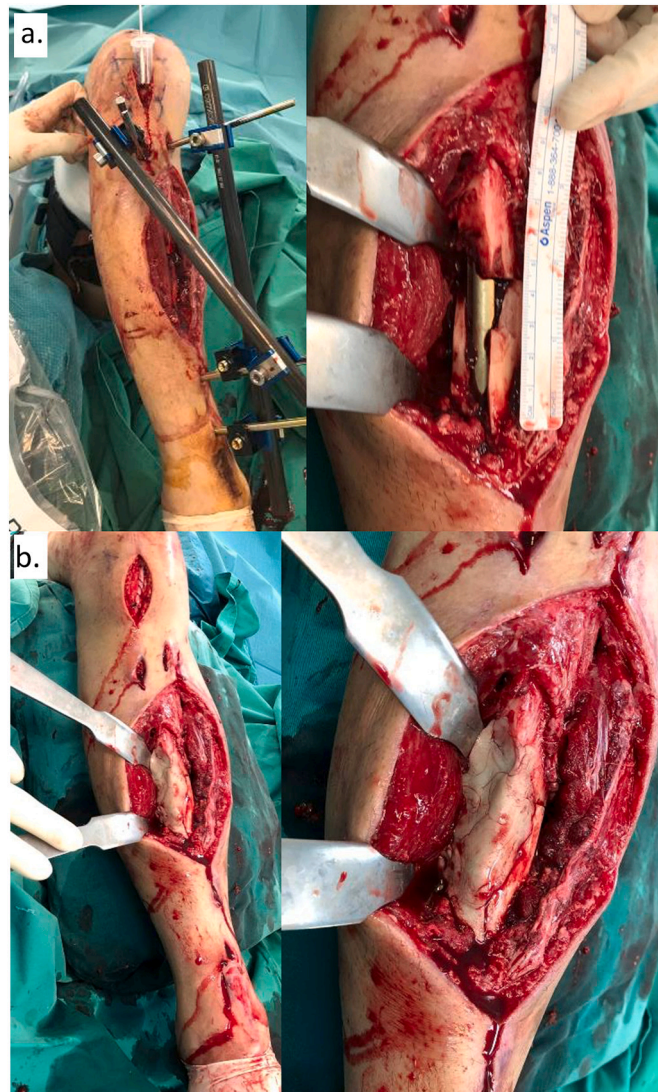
a: Intraoperative clinical photos showing post-debridement anterolateral bone loss of 7 cm. b: Post-operative radiographs showing anterolateral bone loss with interval application of a temporary external fixator.
